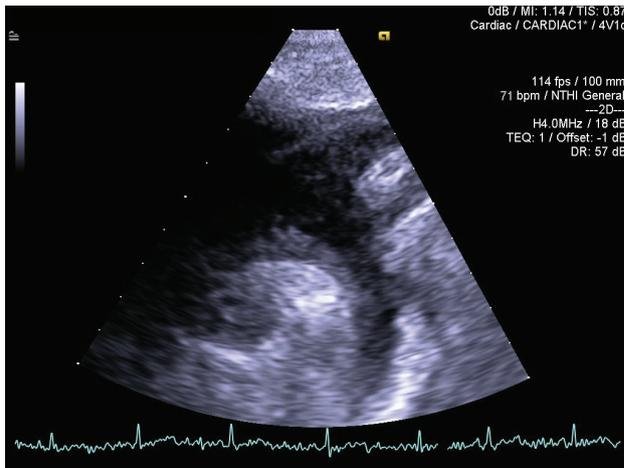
Transthoracic echocardiography suggesting a mobile structure in the aortic arch.
